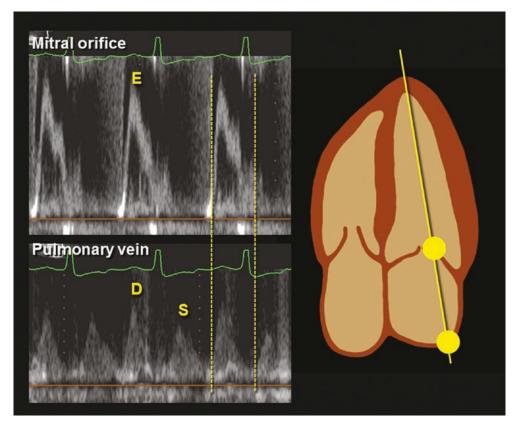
Comparison of pulsed Doppler spectral flow profiles at the level of the mitral orifice (top panel) and pulmonary vein (bottom panel). Note how the diastolic flow profiles are similar in diastole as the atrium serves as
